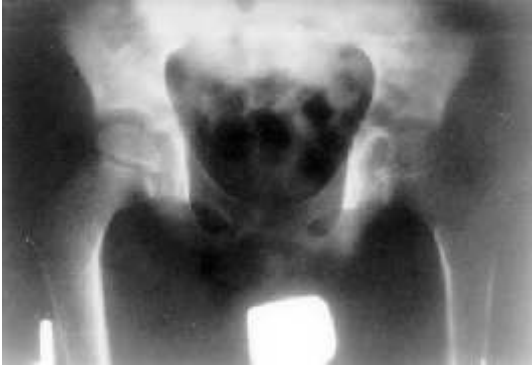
Right ischial bone tuberculosis (radiograph and macrograph), treated no operatively, good anatomical and functional result
